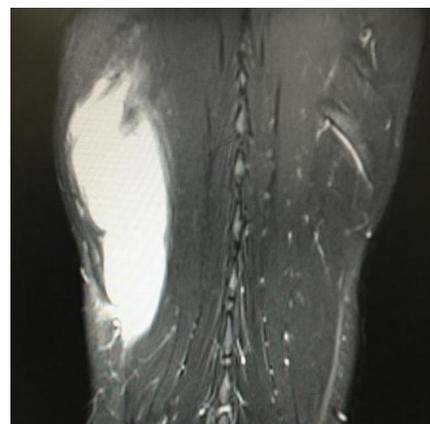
Pre Fibrinolytic therapy MRI
